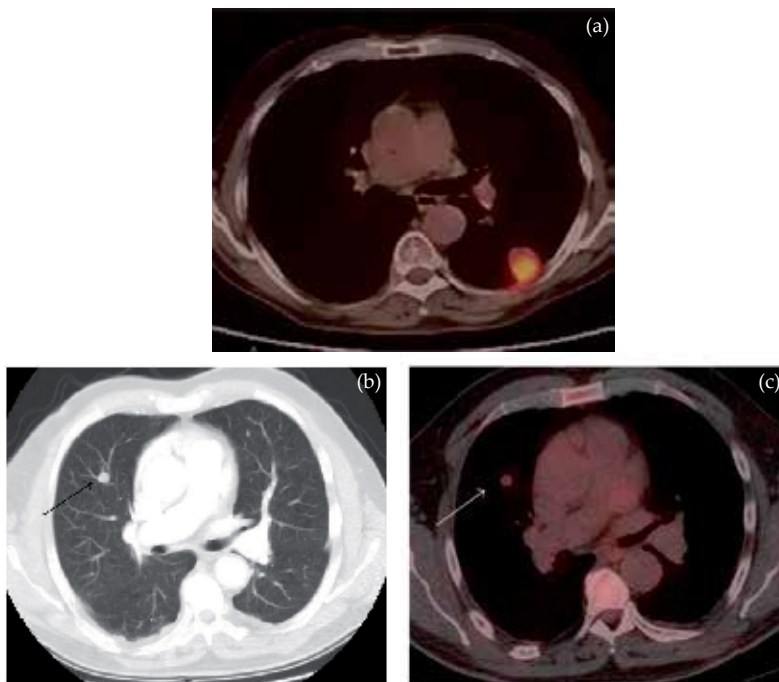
Patient with rectal carcinoma and mildly FDG avid metastases to lung. (a) There is a suspicious right upper lobe lung nodule (arrow) on CT in a patient with prior history of rectal carcinoma. (b) The lesion is only mildly FDG avid (arrow) on fused PET-CT. Based on these images the lesion is not definitively malignant. This may be due to the limited resolution of PET and the small lesion size or reduced cellularity. (c) Lung biopsy was subsequently performed confirming that the lesion (arrow) represented a metastatic deposit from rectal carcinoma. <http://www.hindawi.com/journals/ijso/2011/846512/fig7/>
